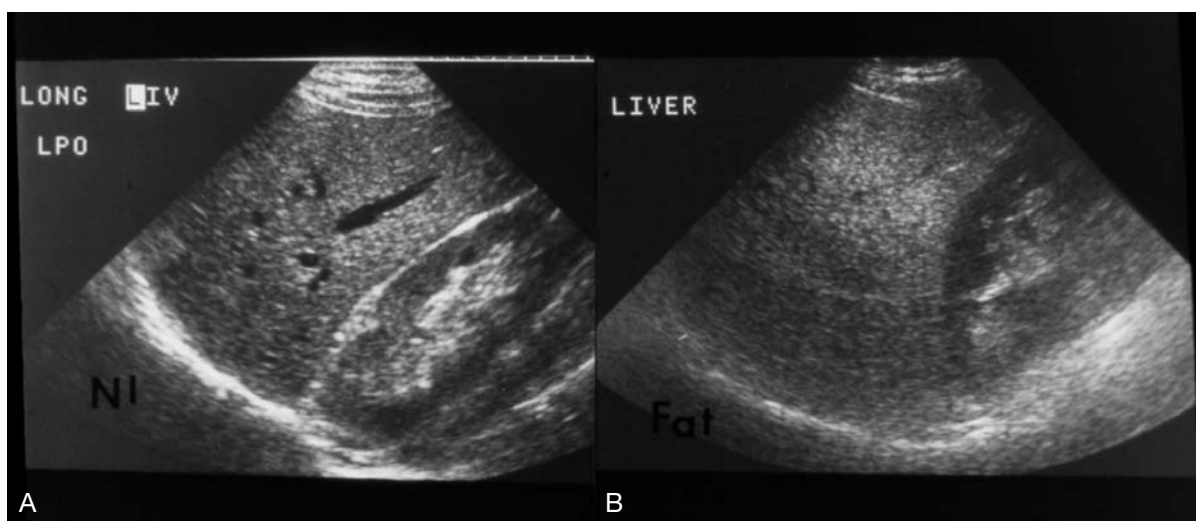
Ultrasonic findings in hepatic steatosis. *A*, Normal liver has distinctive vascular features, whereas, *B*, liver with fatty infiltration has a diffuse bright echotexture and blurring of hepatic vessels.
